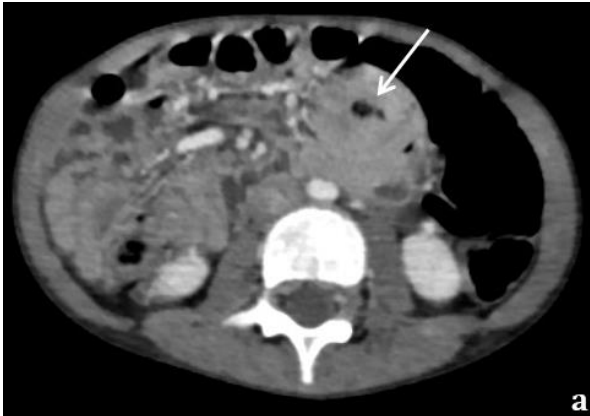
Abdominal CT on axial reconstructions (a, b) showing jejunojejunal intussusception (arrow).
